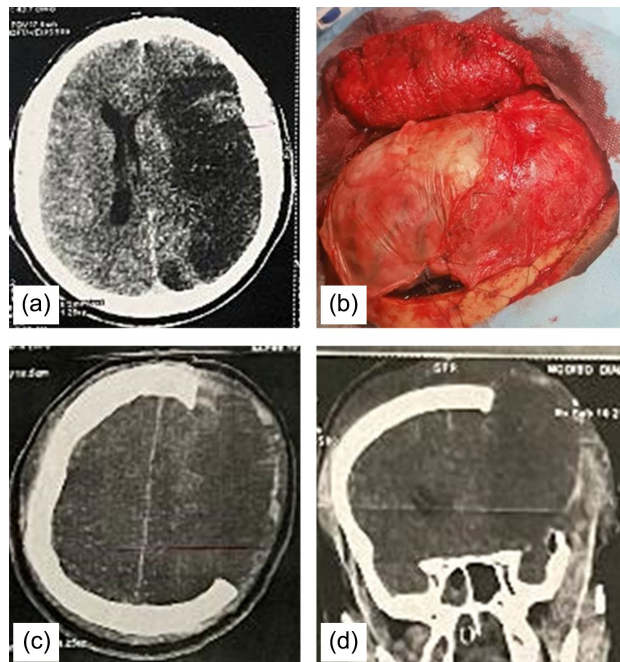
Preoperative CT scan 72 h after stroke onset (a) in patient 1 who underwent craniectomy with duraplasty (b). Postoperative CT scan in axial (c) and coronal (d) views.
